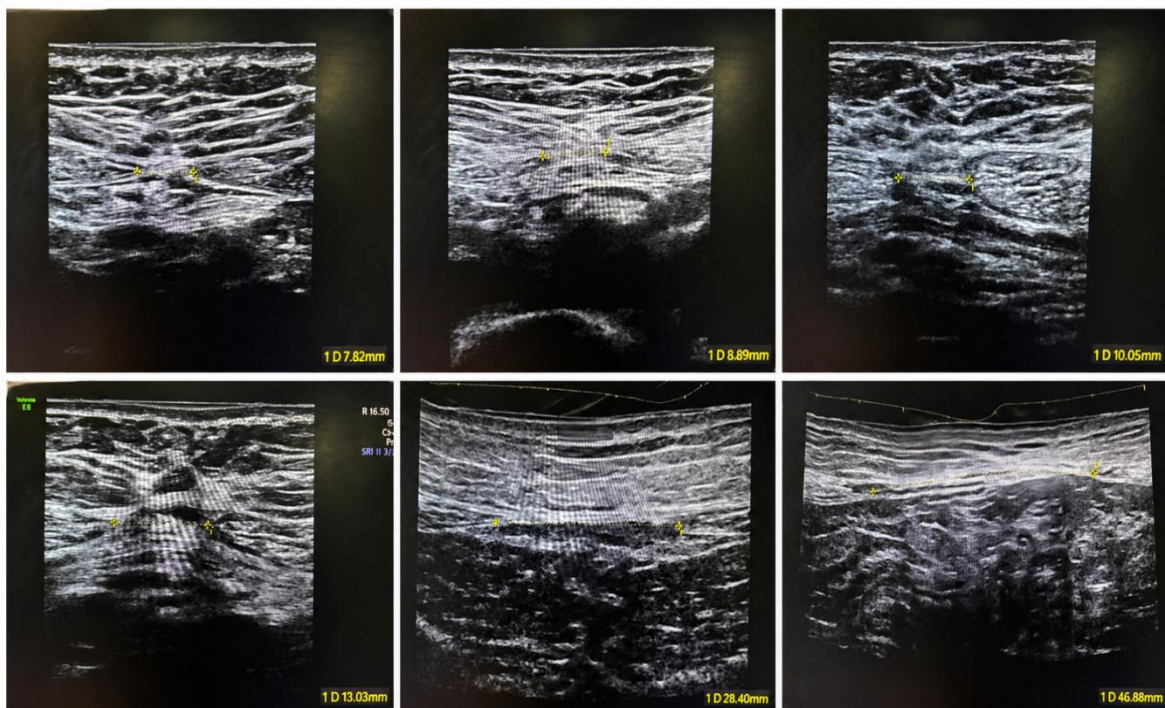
Ultrasound images of different degrees of rectus abdominis diastasis in females
